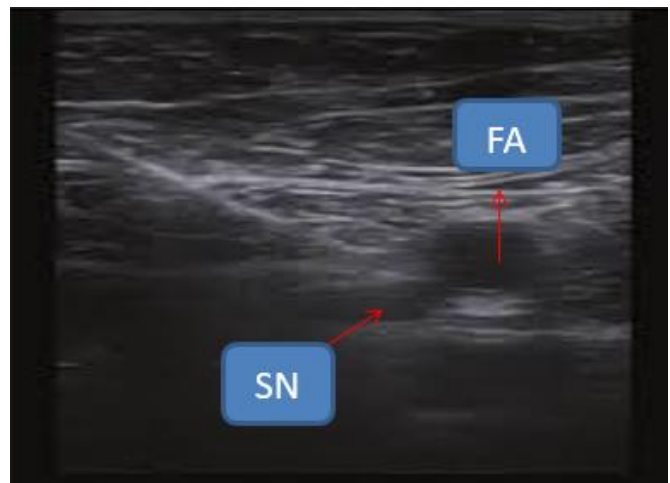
The needle placement near the saphenous nerve medial to the femoral artery is shown under ultrasound guidance (the arrow shows the saphenous nerve and femoral artery).
